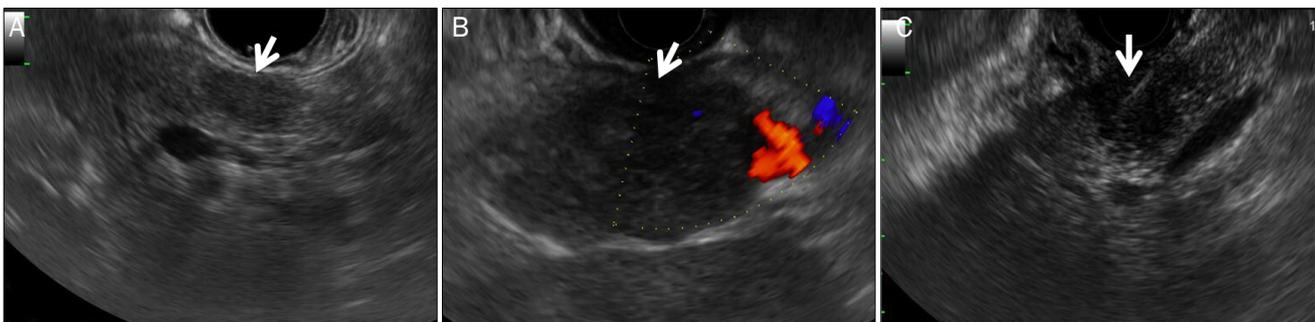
Endosonography images. Radial endosonography revealing 1.5 cm (A, arrow) and 4.5 cm (B, arrow) sized hypoechoic, well-demarked, and round lesions in the body and tail of the pancreas, respectively. (C, arrow) Endosonography-guided fine needle aspiration using 22G needle.
